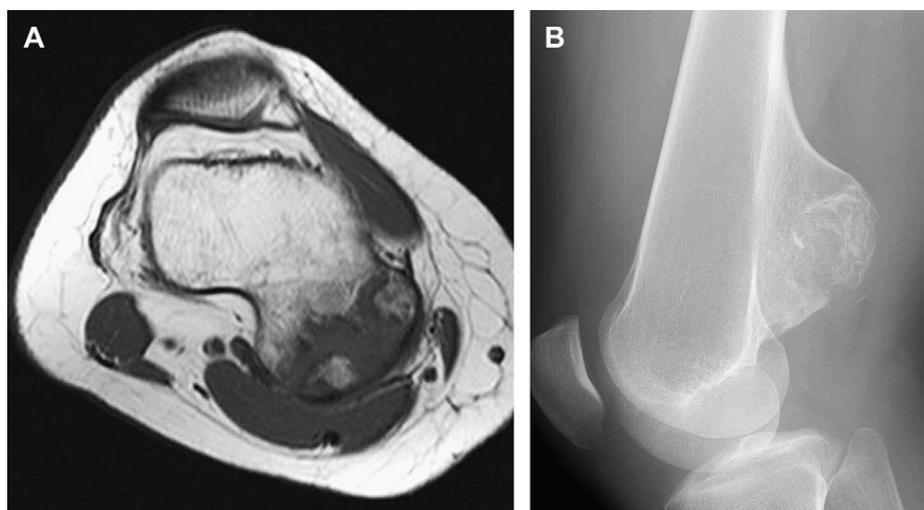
Osteochondroma in the proximal tibia of a 24-year-old man. (A) Axial T1-weighted (TR/TE; 594/16) spin-echo MR image shows a large osteochondroma originating from the distal femoral metaphysis. (B) Corresponding anteroposterior radiograph shows a large, board-based osteochondroma.
